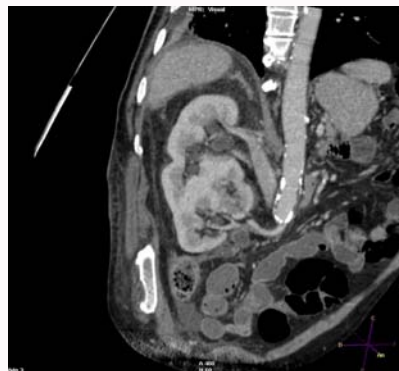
Abdominal CT shows in the absence of kidney in the left abdomen and crossed fused renal ectopia in the right abdomen.
